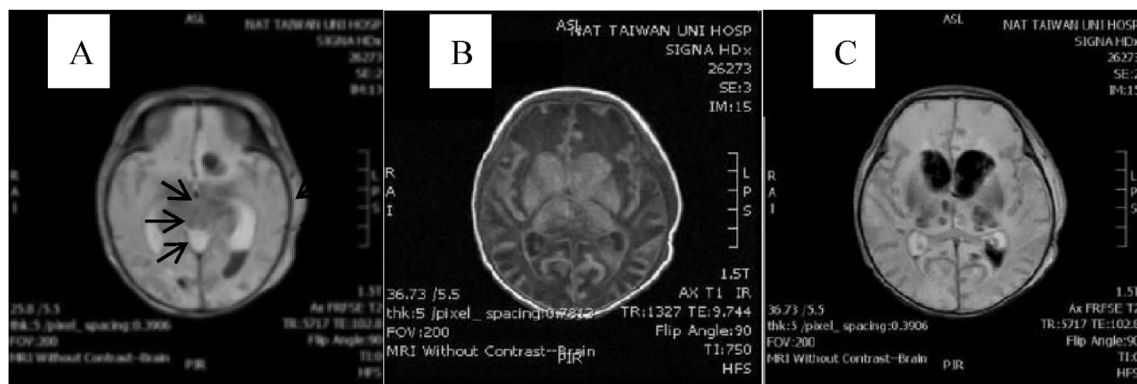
Brain MRI of the neonate. (A) Intraventricular hemorrhage within both frontal horns and occipital horns found at T2 phase (arrow). Hypoxic-ischemic injury to gray matter results in (B) the characteristic T1 hyperintensity () and (C) variable T2 intensity. Injury to white matter results in the T1 hypointensity and T2 hyperintensity due to ischemia-induced edema.
